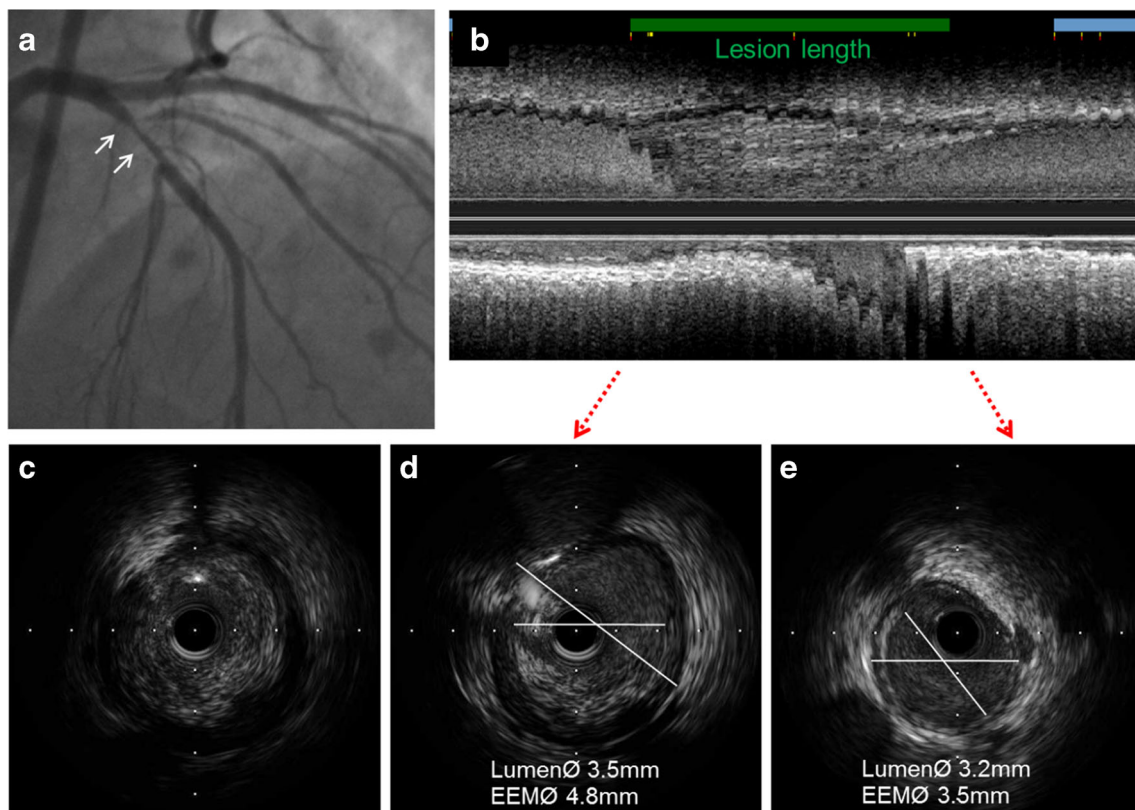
Stent sizing by intravascular ultrasound. a Coronary stenosis (arrows) on angiography. b Intravascular ultrasound-measured lesion length using a longitudinal view. c A large plaque at the minimal lumen
